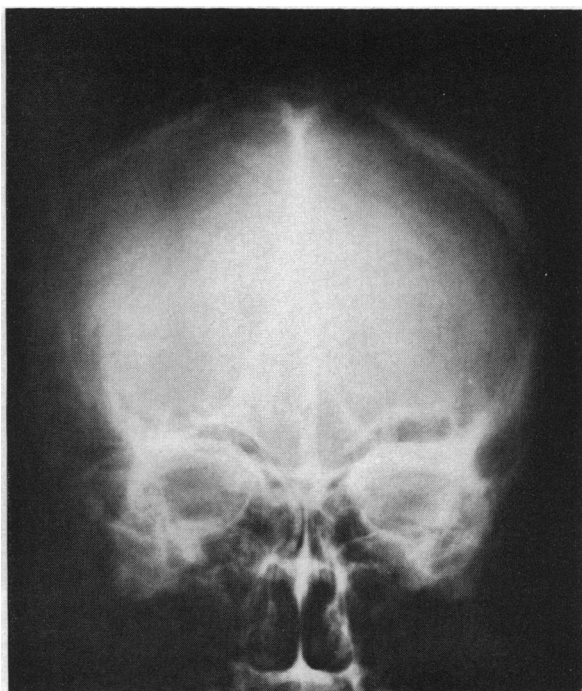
X-ray film of the skull, showing extensive intracranial calcifications.
